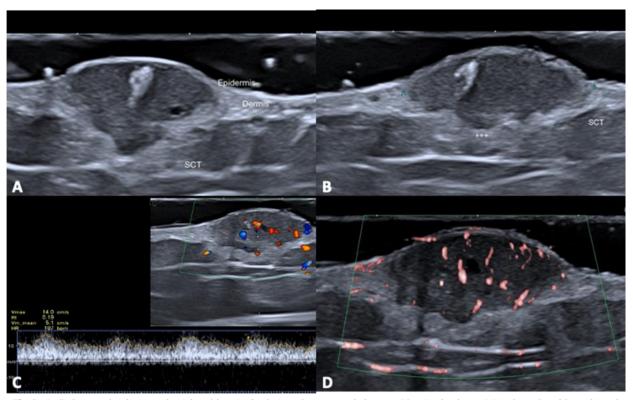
A, B Grey scale ultrasound axial and longitudinal view shows a oval-shape, with mixed echogenicity, dermal and hypodermal mass. Note the lower echogenicity in the upper part and the hyper-echogenicity at the deeper part (+++), the lobulated and convex borders at the deep part of the tumor. C, Power Doppler longitudinal view demonstrates prominent vascularity inside the lesion. D, Color Doppler Duplex, longitudinal view, demonstrates arterial vessels with low resistant flow.
